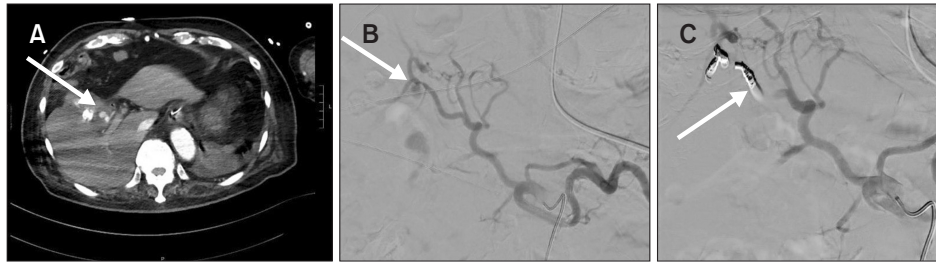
Images for Case 1. (A) Computed tomography showed a ≤ 0.8 cm saccular pseudoaneurysm over the bifurcation of the right hepatic artery (arrow), with no features of active bleeding. (B) The pre-treatment celiac angiography showed a pseudoaneurysm, with no features of active bleeding (arrow). (C) The post-coiling celiac angiography showed complete obliteration of the right hepatic artery by using the sandwich technique (arrow).
